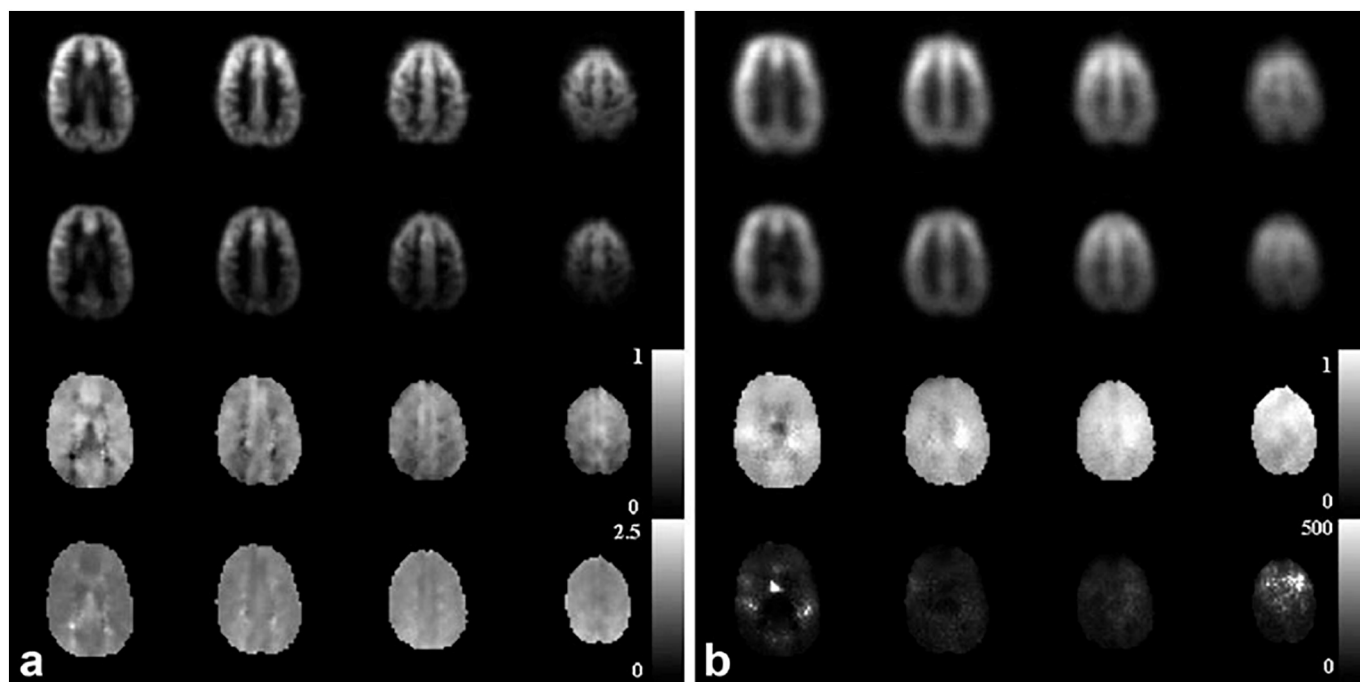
Examples of ASL-DWI images. For both figures a and b, first row shows the average diffusion-weighted (ΔM) maps for b_0 ; second row shows ΔM including diffusion weighting (b_{dw}); third row shows the ratio $\Delta M(b_{dw})/\Delta M(b_0)$. In fourth row, in figure a it is shown the Transit time to the capillary-tissue compartment (τ_a) while in figure b it is presented the exchange rate of water from blood to tissue (k_w) (Lawrence et al., 2012)
